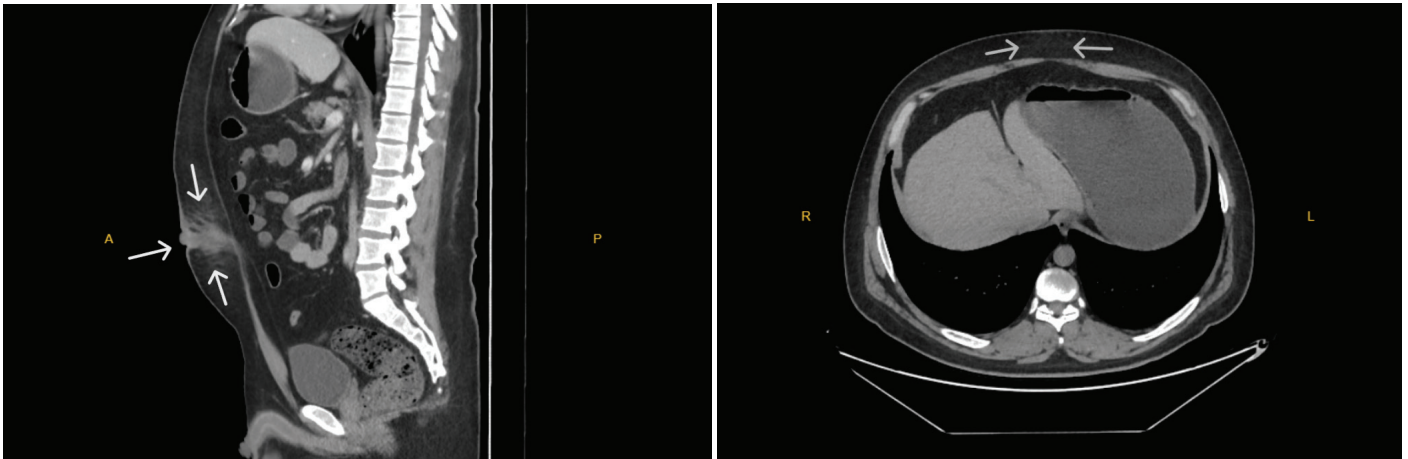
Abdominal CT scan showed an increase in inflammatory density was observed under the skin (with white arrows)
